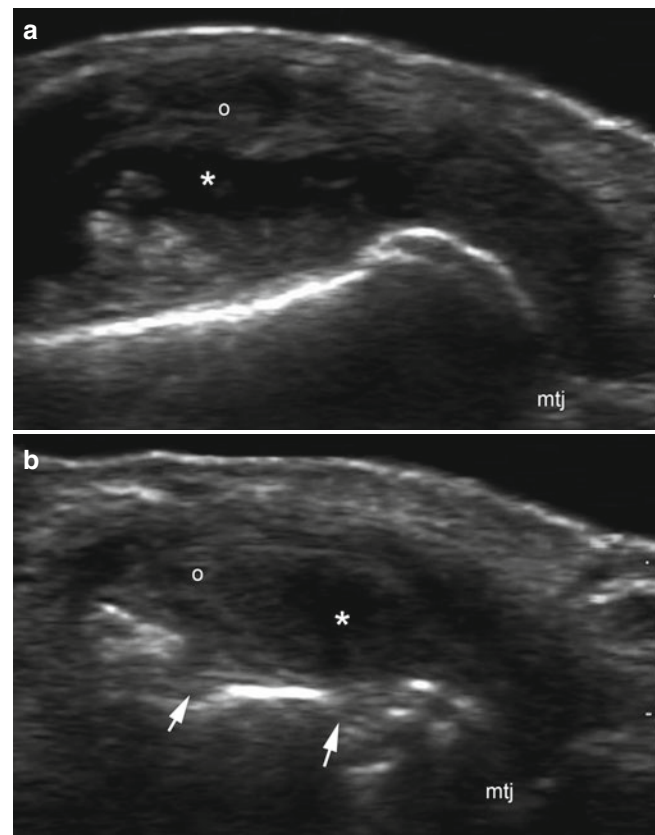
(a, b) Synovitis (Rheumatoid Arthritis). (a, b) Grey scale ultrasound images (longitudinal views; metacarpophalangeal joints; a: ring finger; b: little finger) demonstrate anechoic fluid (*, effusion) and synovial proliferation (o) in the joint. Notice the erosions (arrows) of the bony margin of the proximal phalanx in figure (b). *Abbreviation:* mtj metacarpophalangeal joint
